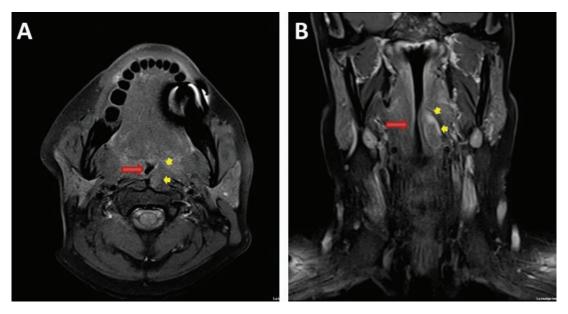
Retropharyngeal tumor compressing the glottis. (A) Cervical MRI axial T1 sequence showing a retropharyngeal tumor (yellow arrows) narrowing the supraglottic space (red arrow). (B) Cervical MRI coronal T2 sequence showing contrast enhancement of the tumor (yellow arrows) narrowing the supraglottic space (red arrow).
